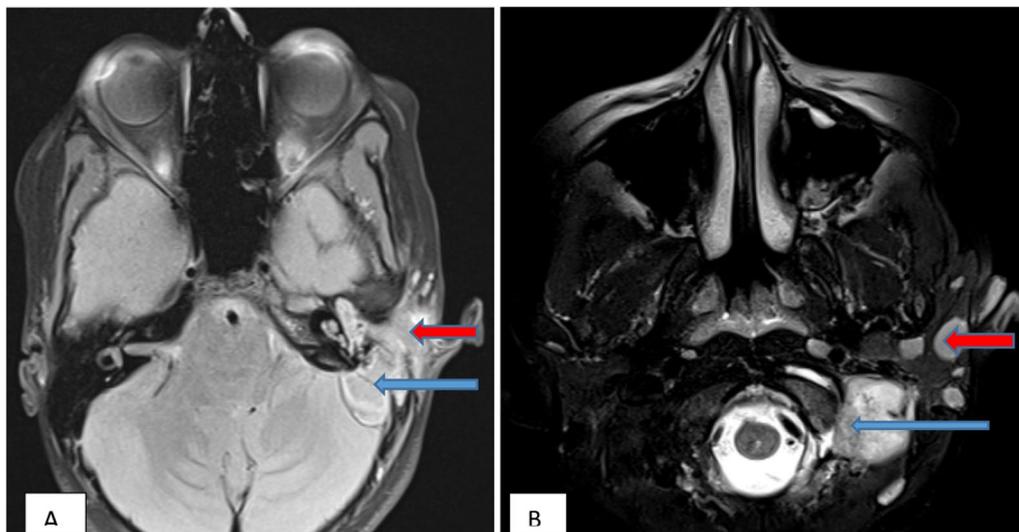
Axial sections of MR image at base of skull shows: A) T1 fat-suppressed image: T1 hypo-intense soft tissue lesion in left external auditory canal (red arrow); extension of soft tissue along left cerebellopontine angle and indenting left cerebellar hemisphere (blue arrow). B) T2 fat-suppressed image: Prominent left intraparotid lymph nodes (red arrow) with T2 hyper-intense soft tissue lesion in the left occipital condyle (blue arrow)
